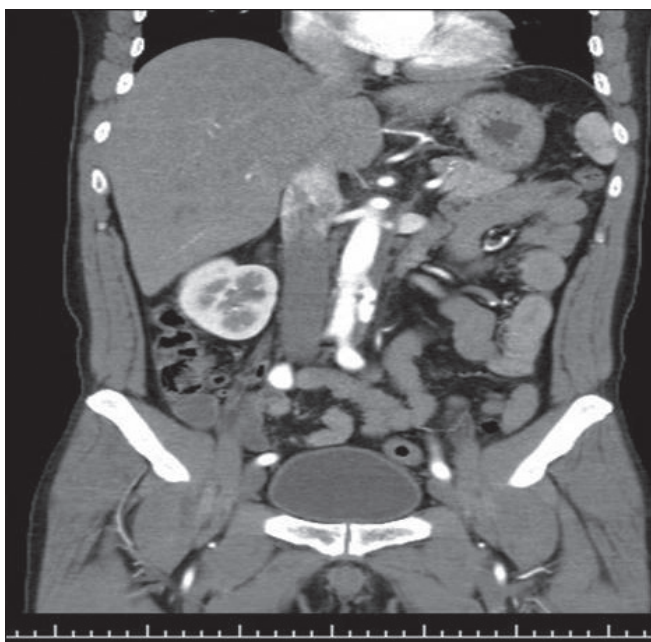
A follow-up contrast-enhanced CT showing aortic dissection with a large primary entry tear in the infrarenal site of the abdominal aorta, extending to the bifurcation of the distal abdominal aorta on day 14 after onset.
